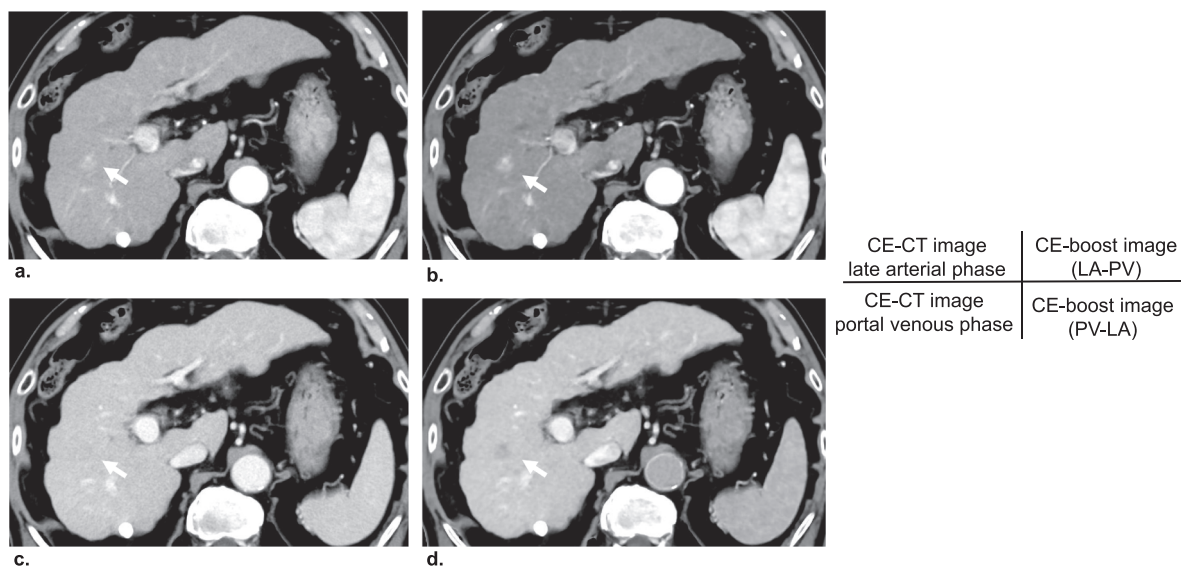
HCC (arrow) in an 85-year-old man. (a) LAP image, (b) CE-boost (LA-PV) image, (c) PVP image, and (d) CE-boost (PV-LA) image. The lesion has faint arterial phase hyperenhancement without washout on the conventional CE-CT images (a, c). The lesion shows nodular high attenuation on the CE-boost (LA-PV) image and low attenuation on the CE-boost (PV-LA) image (b, d). Both readers rated the higher confidence for hypervascular HCC by adding the CE-boost images to the conventional CE-CT images. HCC, hepatocellular carcinoma; LAP, late arterial phase; CE-boost, contrast enhancement boost; LA-PV, PVP subtracted from LAP; PVP, portal venous phase; PV-LA, LAP subtracted from PVP; CE-CT, contrast-enhanced CT.
